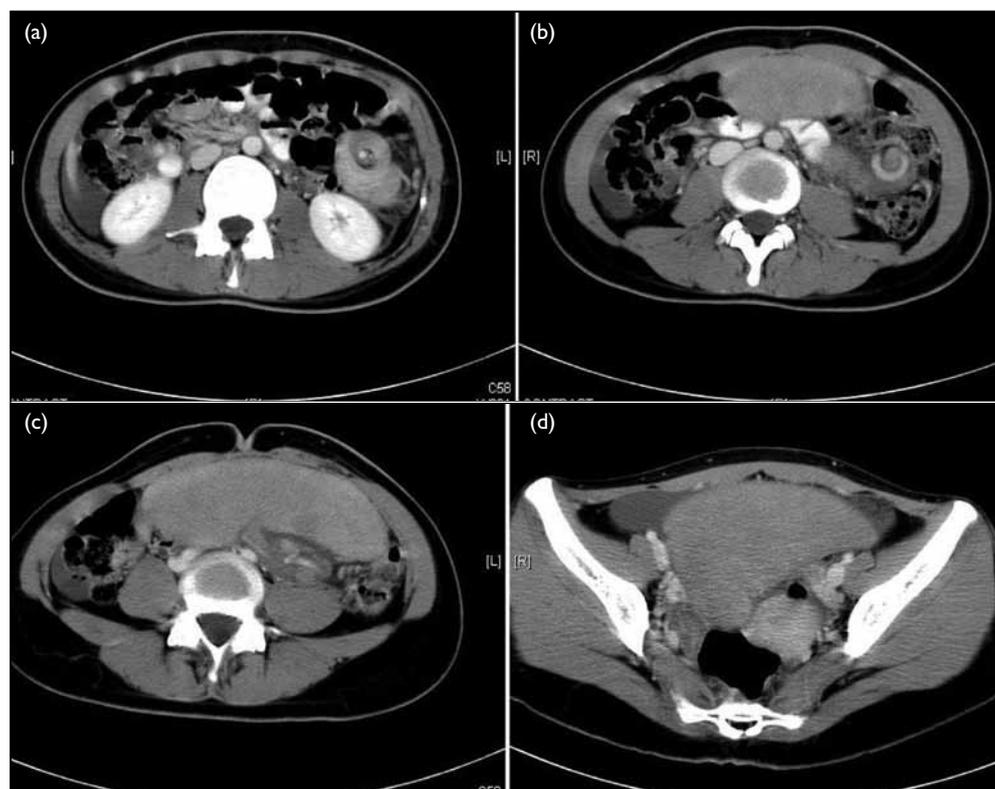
Contrast computed tomography (CT) of the abdomen and pelvis (a, b) CT films showing 'whirl' sign from twisting of vascular pedicle, (c) vascular pedicle entering the spleen, and (d) a significant part of spleen located inside pelvis
